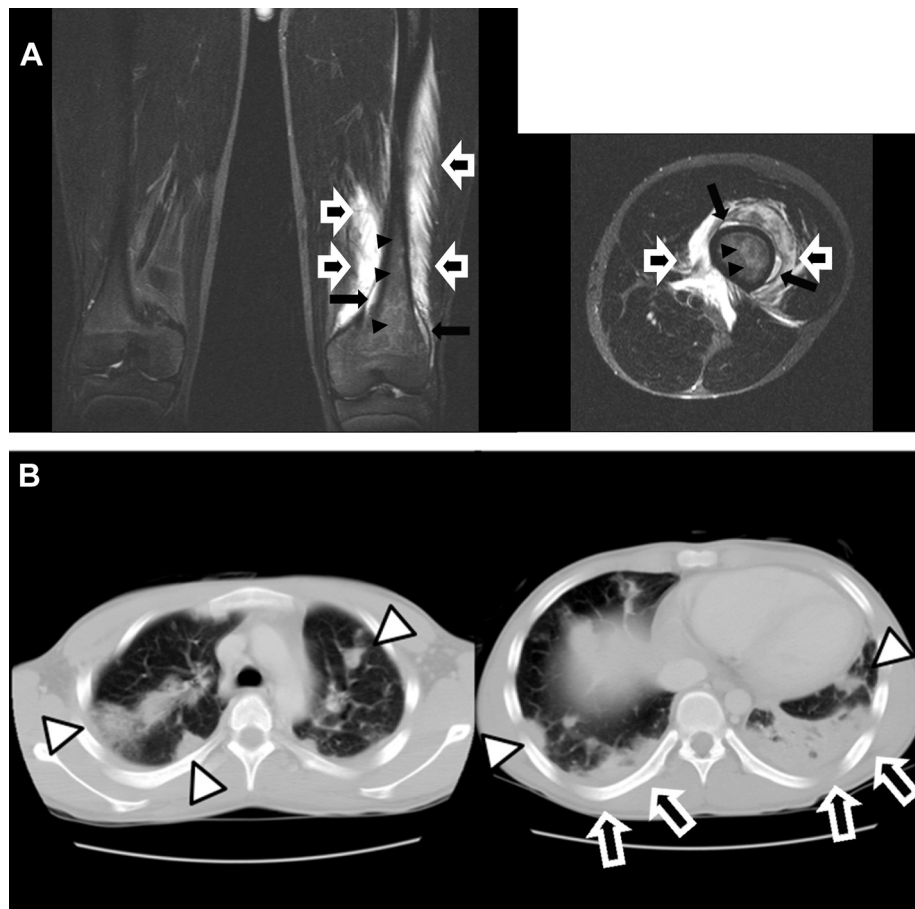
Left femoral osteomyelitis complicated by septic pulmonary embolism in a 15-year-old boy (baseball player). In (A), showing lower limb magnetic resonance imaging (MRI), high-intensity regions were noted in the (intermediate vastus) muscle around the distal end of the left femur on fat-suppressed T2-weighted imaging (pyomyositis, large arrows; subperiosteal abscess, small arrows), and the bone marrow was accompanied by high-intensity regions and weak enhancement (inflammation of the bone, arrowheads). In (B), chest computer-assisted tomography (CT) showed bilateral multiple foci of consolidations (septic embolism, arrows), with pleural effusion and pulmonary infiltrate (pneumonia, arrowheads) at the posterior.
